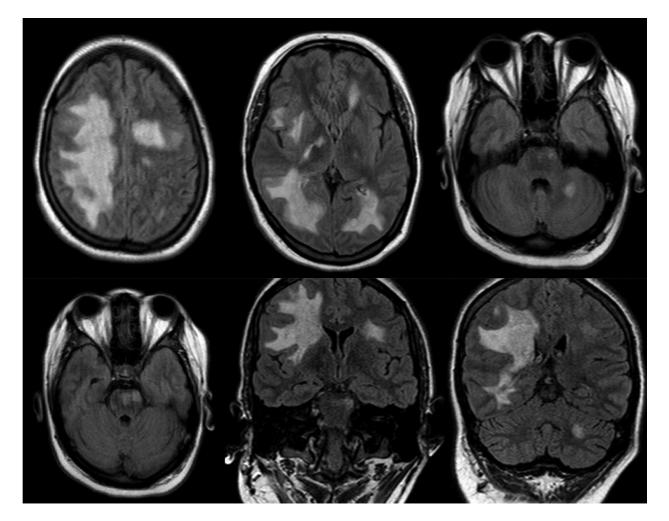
Second MRI (taken almost 2 months after the first MRI). Hyperintense axial T2/FLAIR lesions on the right frontotemporal and parietal lobes (a, b), pons (c, d), and cerebellar (c) regions with heterogeneous gadolinium enhancement. Coronal T2/FLAIR sequence revealing the large extension of lesions, affecting subcortical white matter bilaterally, greater in the right side (e, f), and also the left side of pontine base (e) and left cerebellar hemisphere.
